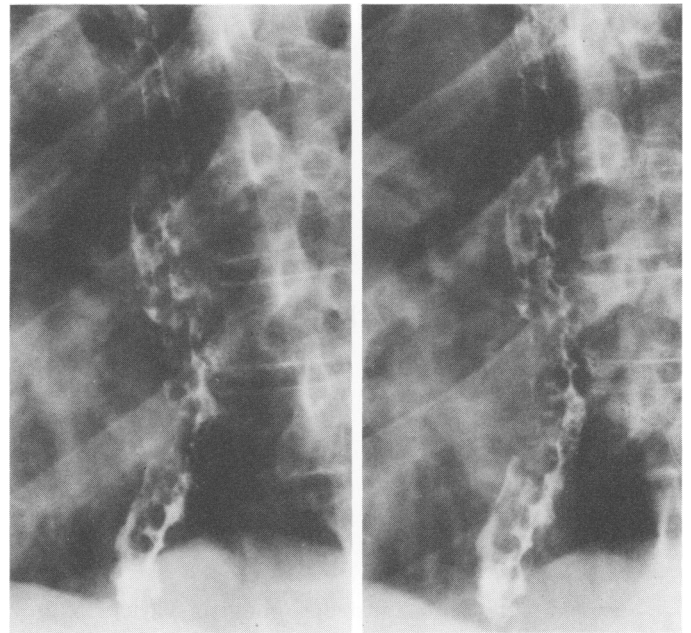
X-ray of the esophagus before sclerosing therapy in an acute (bleeding) instance.
